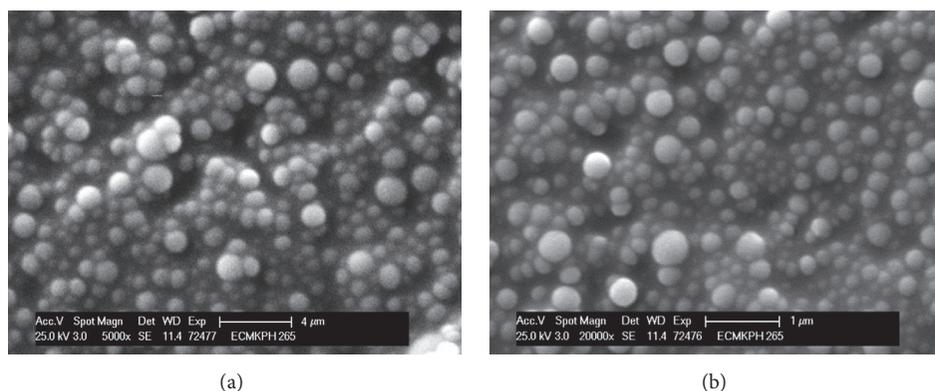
SEM images of ethyl cellulose nanocapsules containing spirooxazine prepared by mechanical stirring (a) and by ultrasound irradiation (b) (samples Nr. 1 and Nr. 3 from Table 1).
